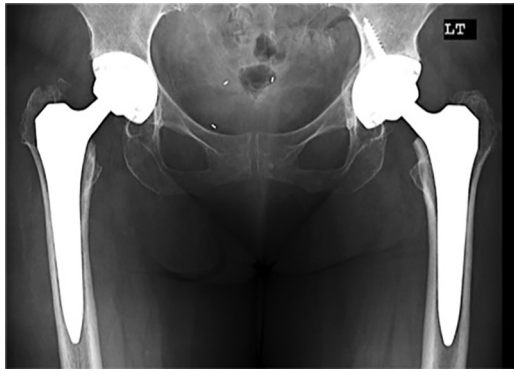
Pelvic Anterior-Posterior radiograph of patient at index presentation (2 years post-primary THA) demonstrate Bilateral THAs with acceptable component positioning, stable asymptomatic fixation and normal bone quality.
